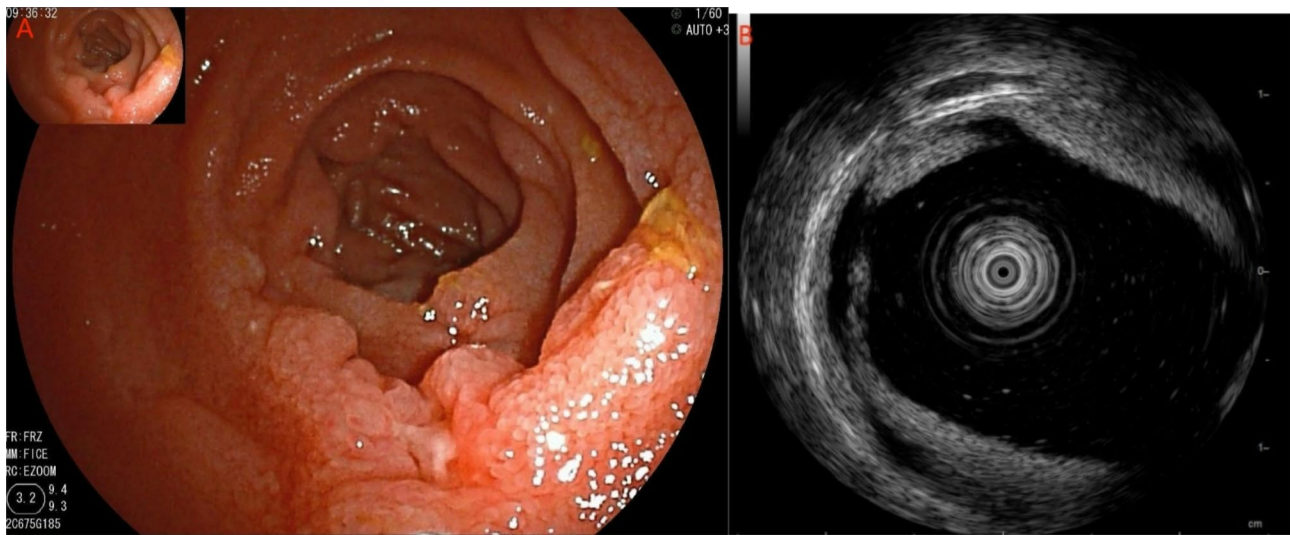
A: Endoscopic findings showing a thin white coated ulcer with a diameter of about 0.6 cm, and nodular changes in the surrounding mucosa, indicating mild disease activity. B: Small intestinal endoscopic ultrasound showing clear differentiation of the layers of the intestinal wall and mild thickening of the intestinal wall
